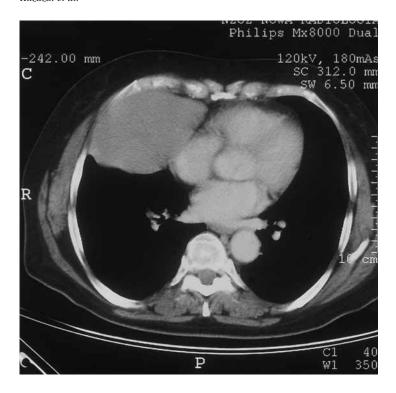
CT scan showing a 10 cm mass adherent to the anterior chest wall, the right atrium, the superior vena cava and the ascending aorta.
